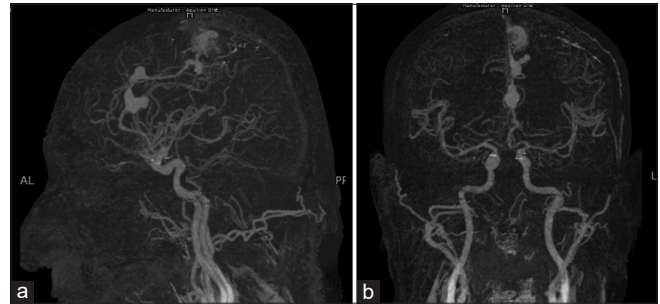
Head computed tomography angiogram at the time of presentation revealing a compact arteriovenous malformation in the left frontal lobe and three aneurysms in the distal anterior cerebral artery region. (a) Sagittal view, (b) coronal view.
